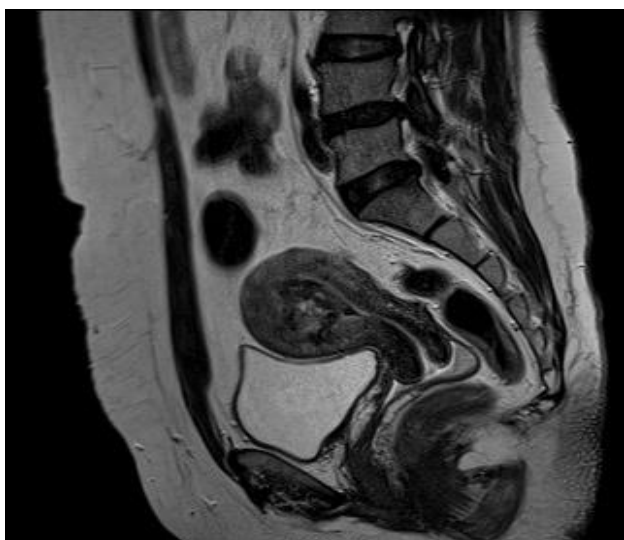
Sagittal T2 weighted image of the MRI pelvis showing multiple tortuous flow voids in the endometrial cavity consistent with the high velocity vascular channels.
